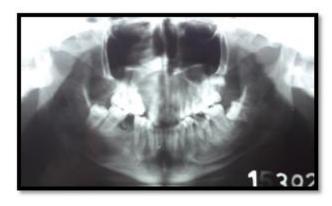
OPG and water's x-ray showed radioopacity with displacement of tooth and destruction of maxilla bone extended to right maxillary sinus
